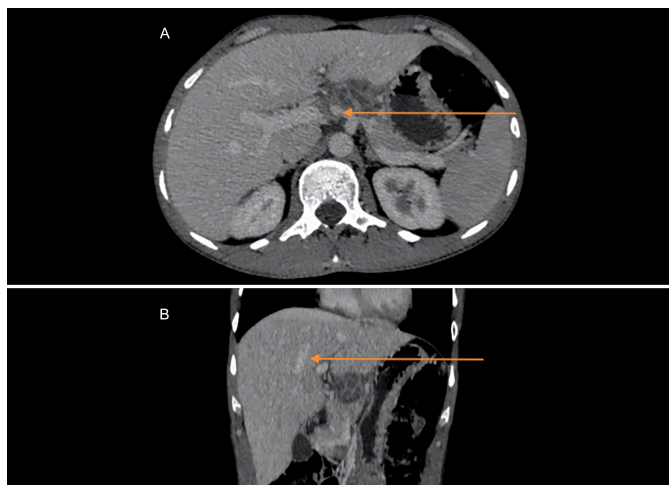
CT scan of abdomen showing a heterogenous mass in the pancreatic body (Arrow) extending into the gastro-hepatic recess in cross-sectional (A), and sagittal sectional view (B).
